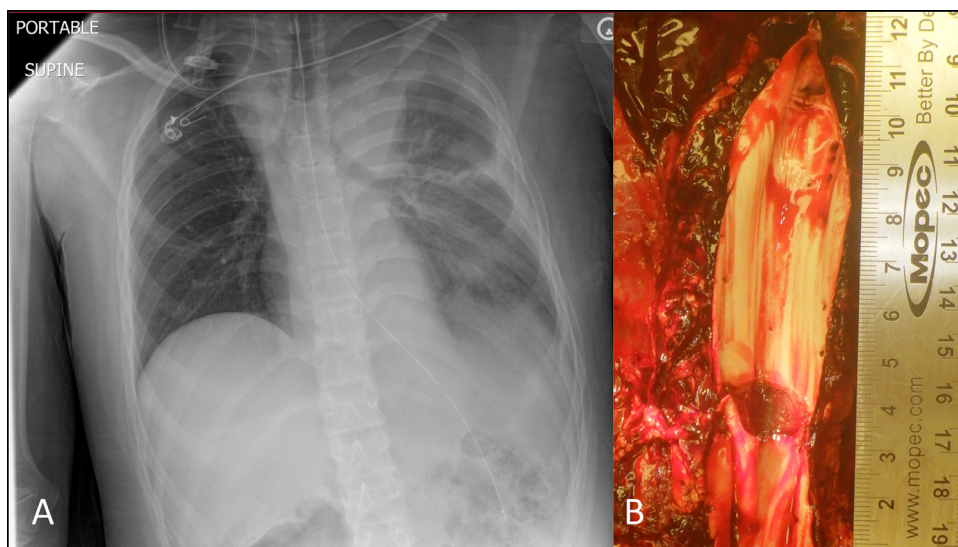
(A) Chest x-ray of a 15-year-old boy with vascular Ehlers-Danlos syndrome presenting with sudden atraumatic onset back pain demonstrating a widened mediastinum. The patient became hypotensive and had a cardiac arrest. (B) The autopsy demonstrated full-thickness rupture of the descending thoracic aorta at T9 to T10 with dissection to the level of the aortic bifurcation.
